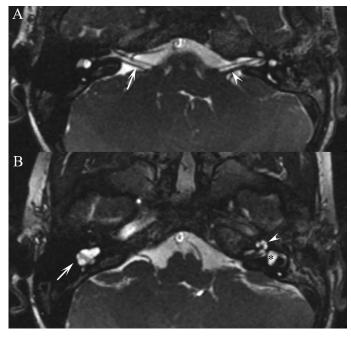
High resolution T2 weighted MRI (FIESTA) of the inner ears. A. The right vestibulocochlear nerve (arrow) is hypoplastic when compared to its left counterpart (arrowhead). B. The right cochlea is absent and the vestibule is inseparable from the horizontal semicircular canal (arrow). Normal left cochlea (arrowhead) and vestibule (black asterix).
